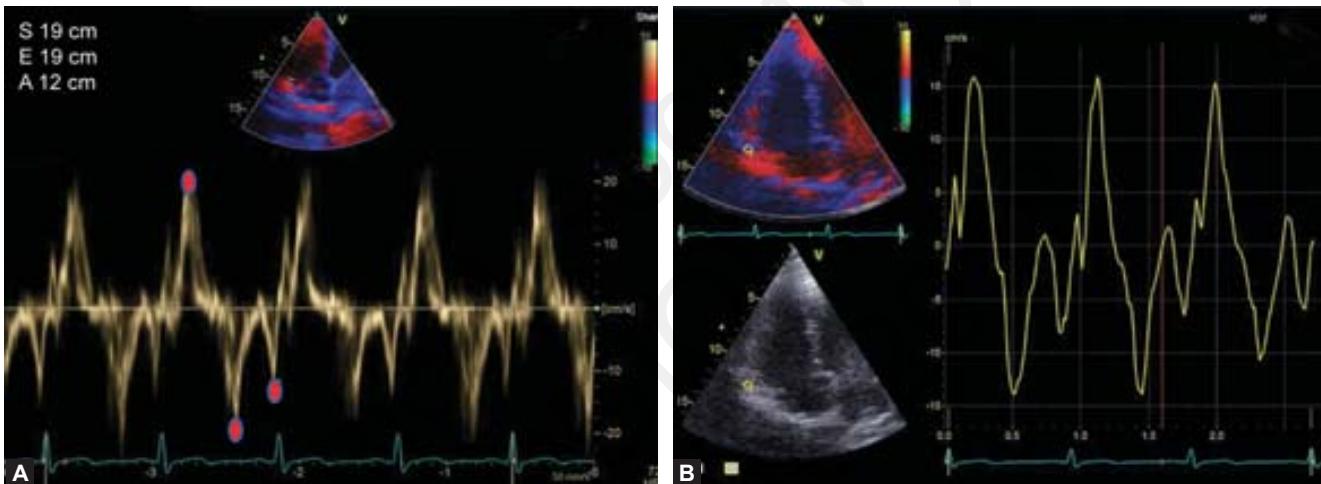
A, Pulsed tissue Doppler from anterior tricuspid annulus; B, Tricuspid tissue Doppler velocity from color two-dimensional tissue Doppler.
